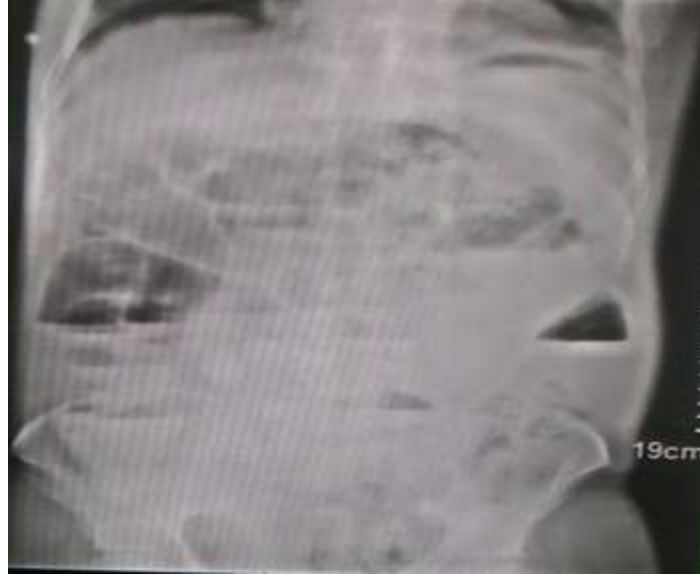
X-Ray Erect abdomen showed multiple air fluid level suggestive of obstruction.
